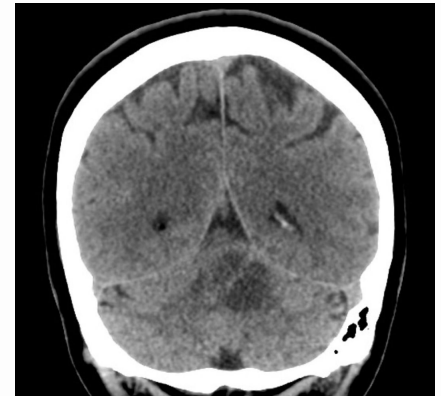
Coronal image of noncontrast CT brain showing multiple cystic lesions within in the right and left cerebellar hemispheres. Creative Commons license: Case courtesy of Dr. Bruno DiMuzio, Radiopaedia.org, rID: 41395.
